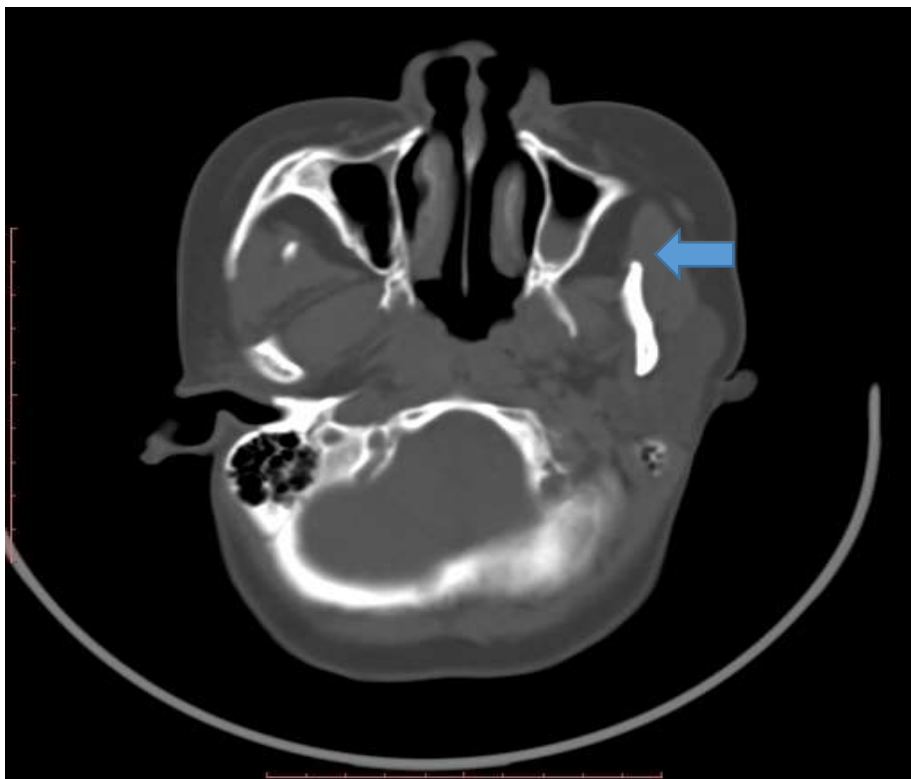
Axial head CT scan bone window of 35 year old female who presented with 8 month history of chronic headache showing bilateral maxillary sinusitis
